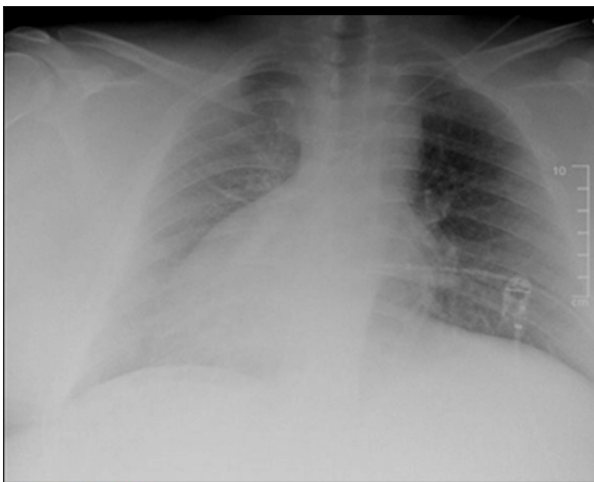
Chest X-ray showing dextrocardia and deformity of the right fourth rib.
